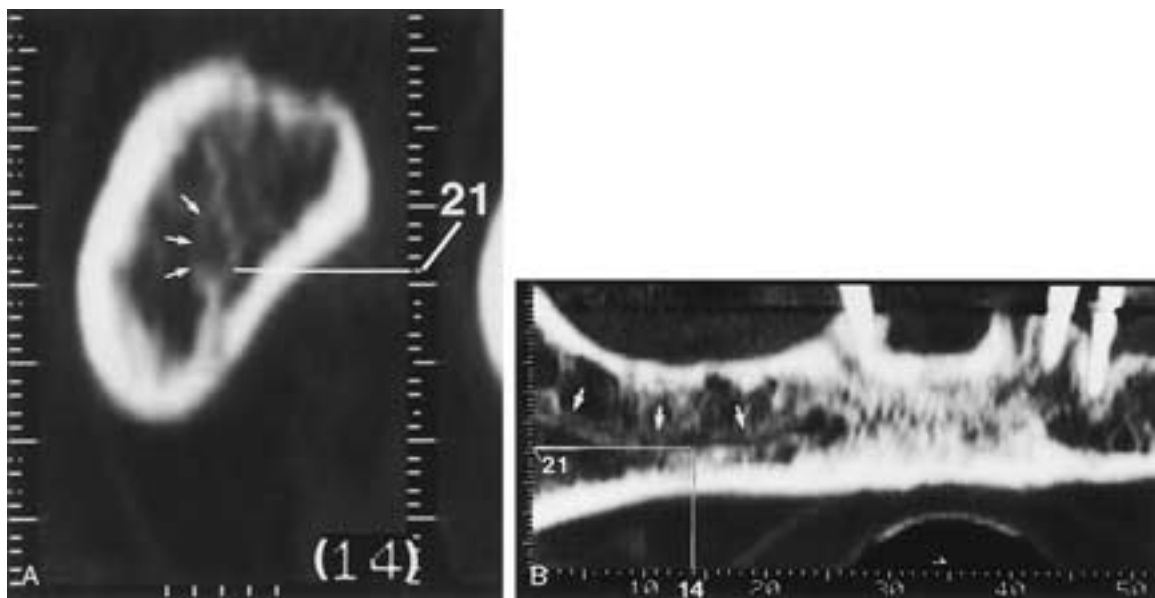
Triangulation. When the inferior alveolar canal is not initially seen on the cross-sectional images, as in this case (A), its location can be determined by triangulating from the panoramic (B) or axial image, as described in the section of text on “Identifying the Mandibular Canal”. The inferior alveolar canal is indicated by arrows. (From Abrahams JJ. CT assessment of dental implant planning. *Oral Maxillofac Surg Clin North Am* 1992;4:1–18.)
